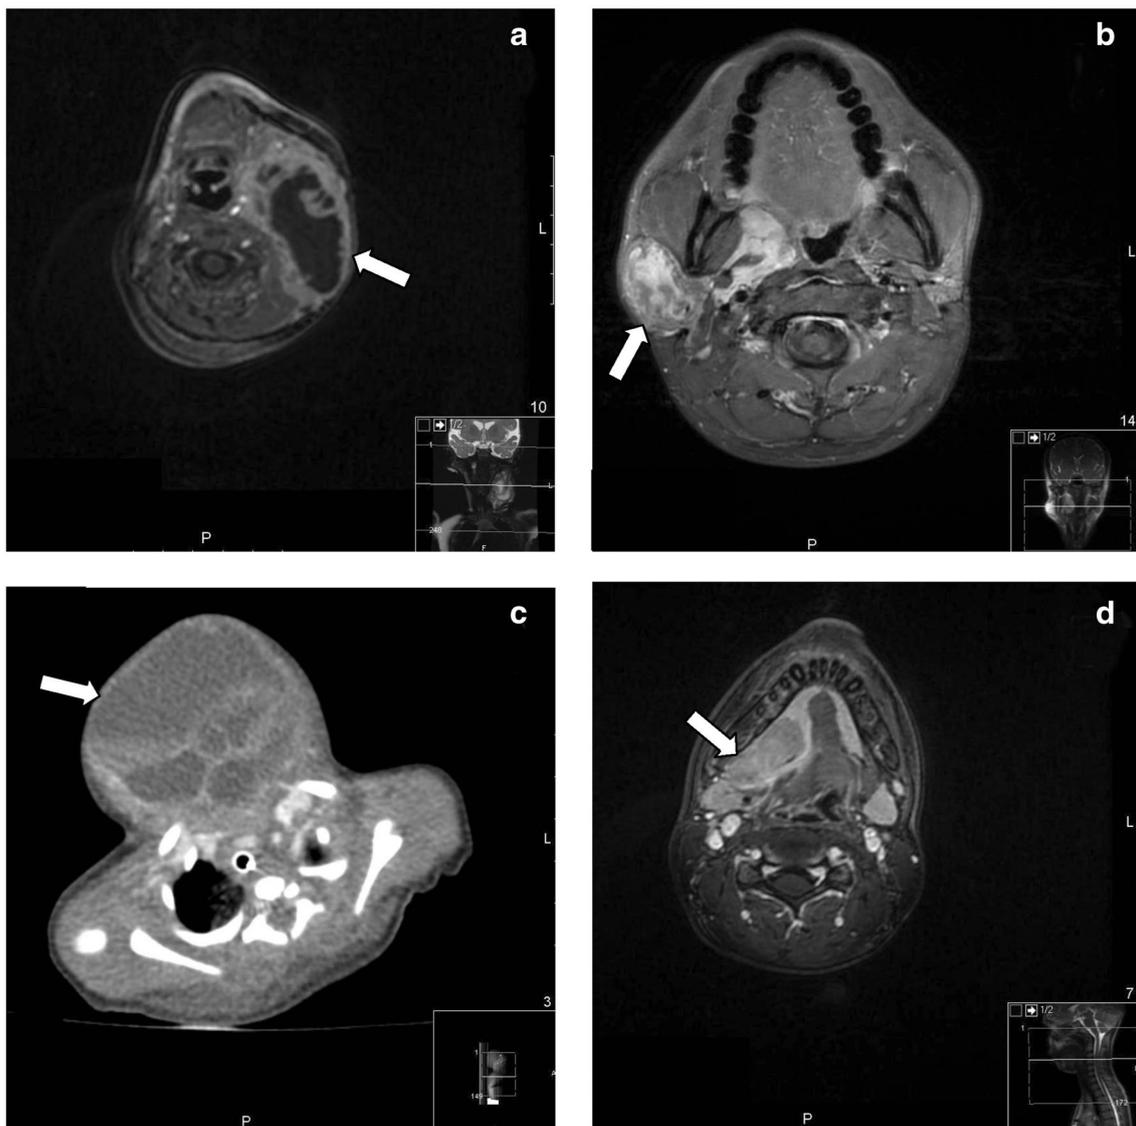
Imaging findings from children with neck masses (white arrows): congenital/developmental lesions and tumors. a T1-weighted MRI: left-sided branchial cyst of the third arch (maximum dimension 60 mm) in a 5-month-old female. b T1-weighted MRI: right-sided lymphangioma (maximum dimension 29 mm) in a 15-year-old male. c CT: right-sided
